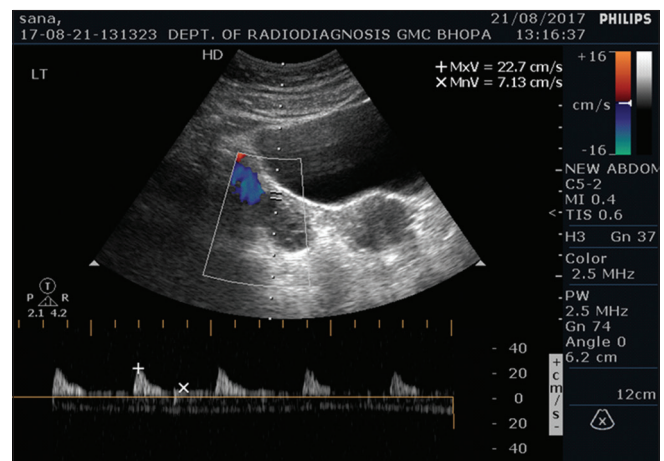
Color Doppler study in a control showing reduced systolic and diastolic and high resistance flow
